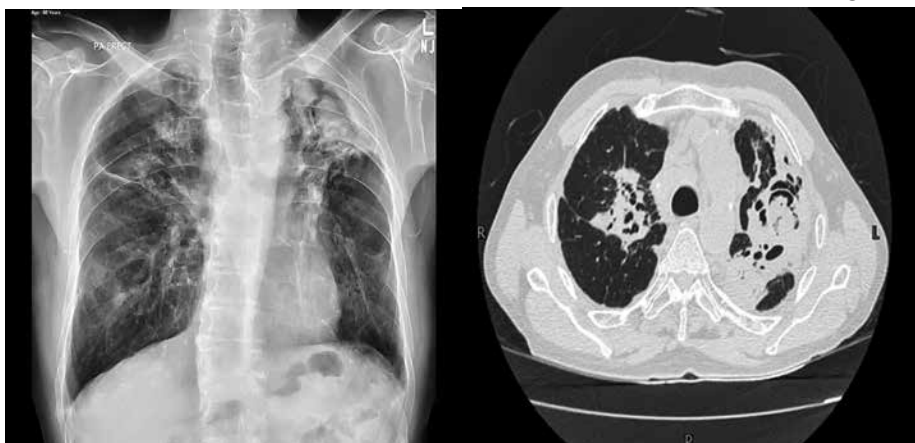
Chest radiograph and CT scan of a patient with chronic cavitary pulmonary aspergillosis. Panel A shows loss of lung volume, pleural thickening and fibrocavitary changes in the upper zone of left lung. Air crescent sign is also visible in this area. Fibrocavitary changes are also seen in the upper zone of right lung. Panel B shows pleural thickening, fibrocavitary changes and multiple aspergilloma in left lung and fibrocavitary changes in right lung.
